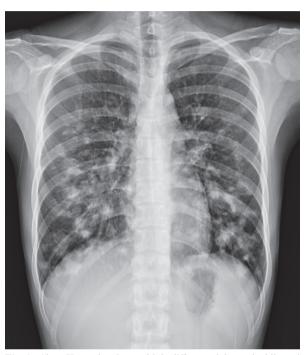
Chest X-ray showing multiple diffuse nodules at the bilateral lungs, mainly at the middle and lower lung fields.
